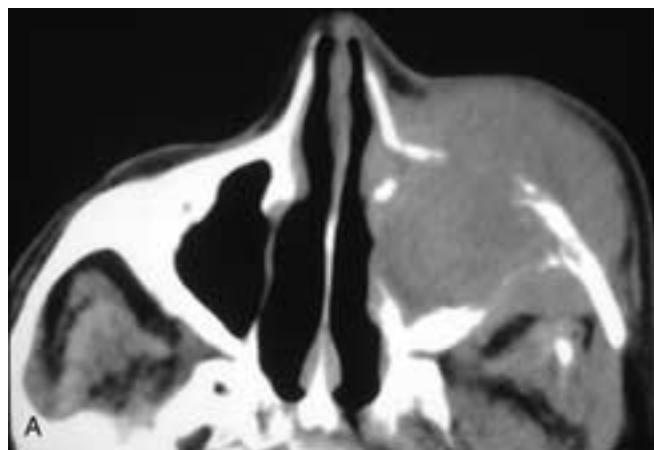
Axial (A) and coronal (B) CT scans show a large left maxillary sinus mass that has destroyed most of the sinus walls and the body of the zygoma. The tumor extends into the left lower ethmoid complex, the left orbit, and the left retromaxillary fat in the infratemporal fossa. This patient had a squamous cell carcinoma.
